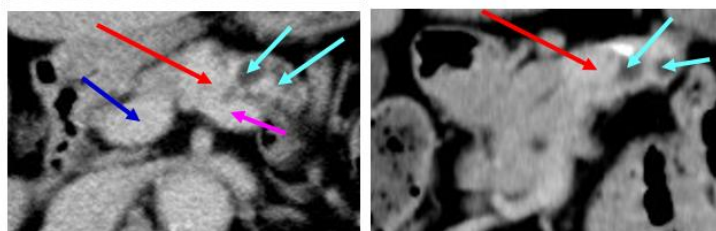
Abdominal CT Scan (Transvers and Coronal Views)
